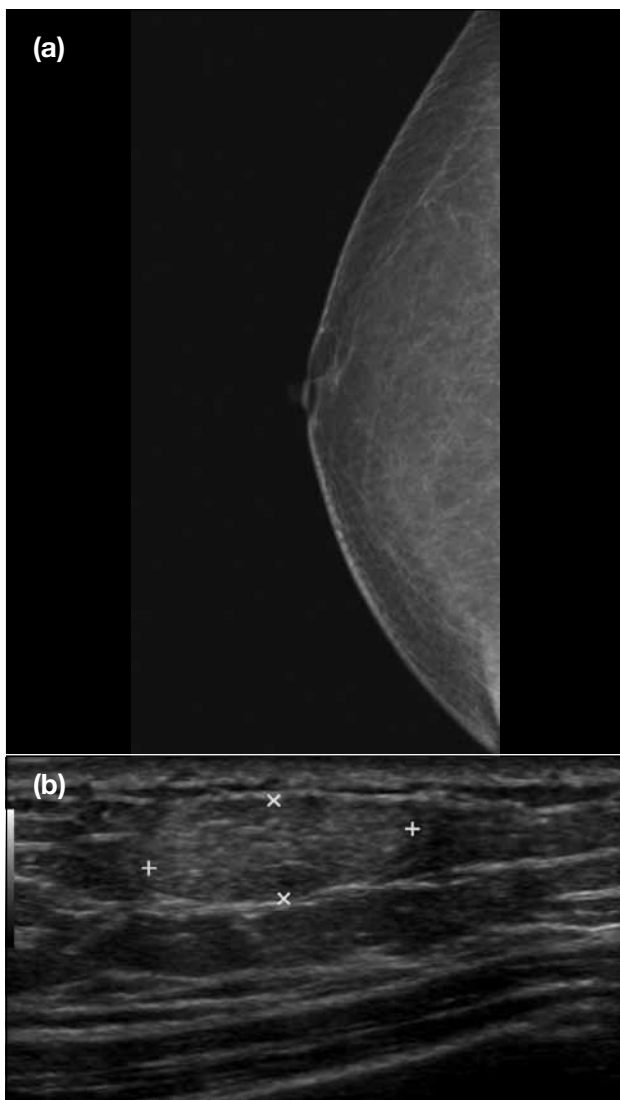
Another patient with a lipoma: (a) Craniocaudal mammogram reveals no definite mass. (b) Supplementary ultrasound of the palpable area reveals a parallel, homogeneous, mildly hyperechoic encapsulated mass, suggesting lipoma.
